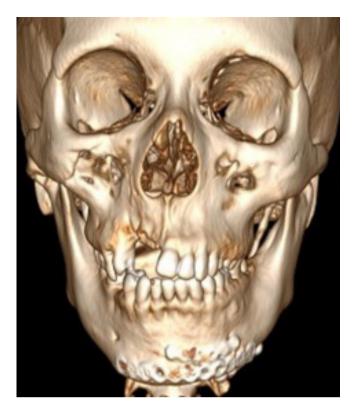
Three-dimensional reconstruction of face CT scan displaying osteosynthesis in the left mandibular parasymphysis region.
